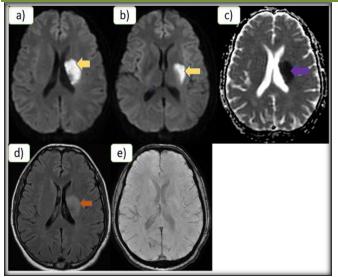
(a-e) showing Acute infarct in left corona radiata and left basal ganglia. Fig a-c, showing an area of diffusion restriction (yellow arrows) with corresponding low ADC values (purple arrow) in the involved region. Fig d- FLAIR hyperintensity (brown arrow) in the affected region. Fig e – SWI showing no significant findings.
